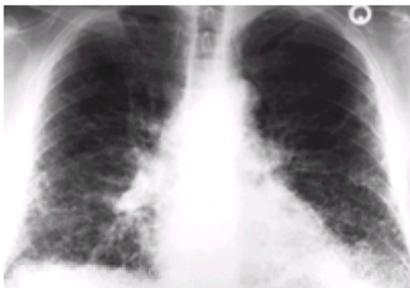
Honeycombing is present, predominantly at the lung bases, in this case of severe interstitial pulmonary fibrosis. Note that fibrosis is so severe that the margins of the chest wall, diaphragm, and mediastinum are all rendered indistinct and shaggy. Early findings of interstitial pulmonary fibrosis may be seen on high-resolution chest CT before becoming visible on standard chest radiographs.
